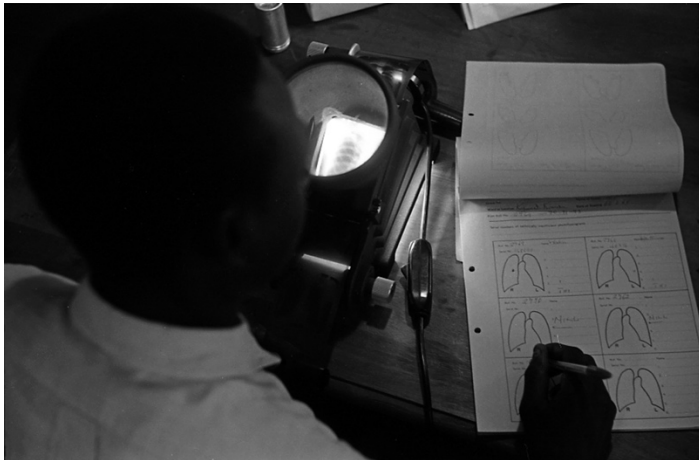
“X-ray film reading.” 1964, HQ31064, WHO Photo Library.
